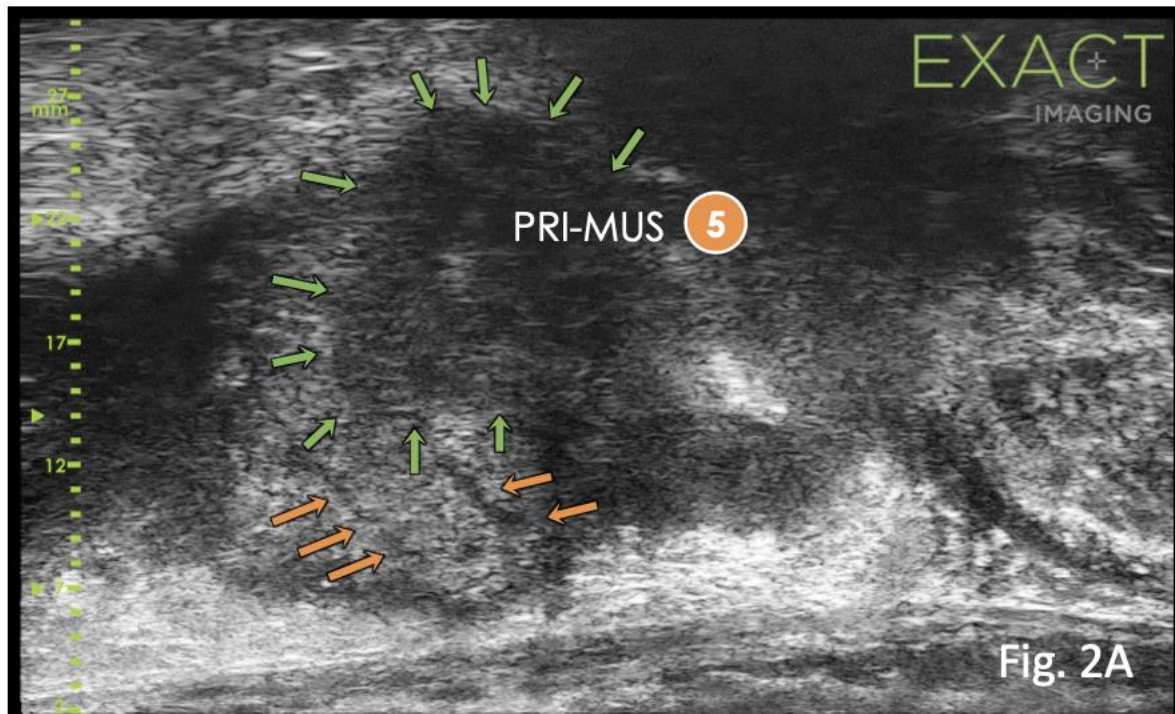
Small left middle-to-apical lesion seen on microUS as PRI-MUS 5 (A) and on mpMRI (2B - T2 axial; 2C - DWI b1400 values; 2D – DWI ADC map; 2E – DCE) classified as PI-RADS 4, highlighted by green arrows. Pathology evaluation of biopsy cores confirmed ISUP 3 disease with 75% pattern 4 and 6mm of maximal cancer core length. Orange arrows in fig. 2A show needle tracks of original diagnostic biopsy at initiation of AS, only tangentially approaching the lesion, likely resulting in ISUP 1 misclassification.
